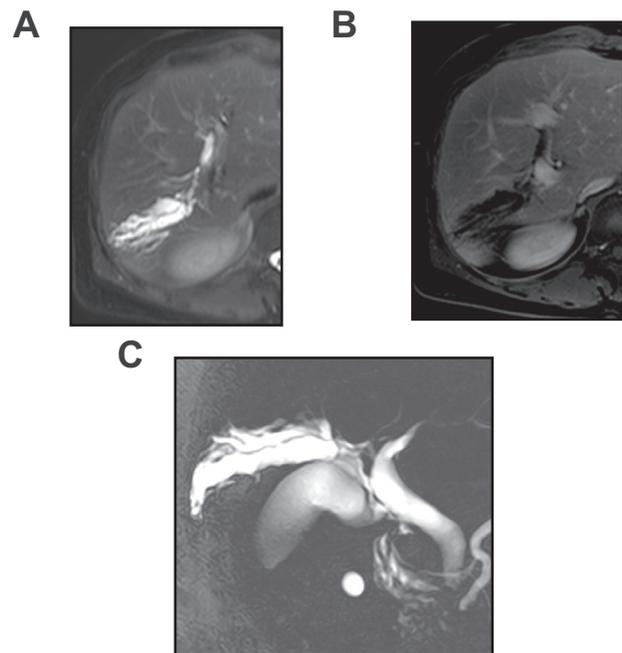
Images in a 57-year old-woman with surgically confirmed intraductal papillary neoplasm of the bile duct with low- or intermediate-grade intraepithelial neoplasia. (A) T2-weighted image shows a focal stricture-like lesion with proximal duct dilation. No intraductal visible mass is identified. (B) Portal phase contrast-enhanced MR image does not show bile duct wall thickening or adjacent organ invasion. (C) MR cholangiography image shows bile duct dilatation with a focal stricture-like lesion. MR, magnetic resonance.
